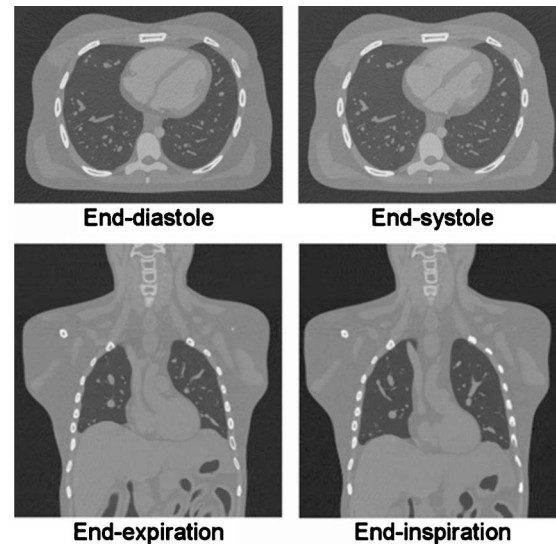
Cardiac-gated (top) and respiratory-gated (bottom) CT images generated using the 4D female XCAT.
